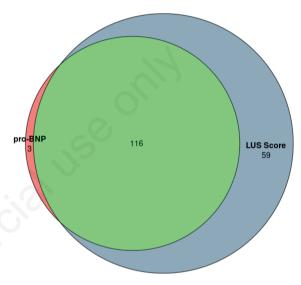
Eulero-Venn plots of pro-B-type natriuretic peptide and lung ultrasound scan records.
